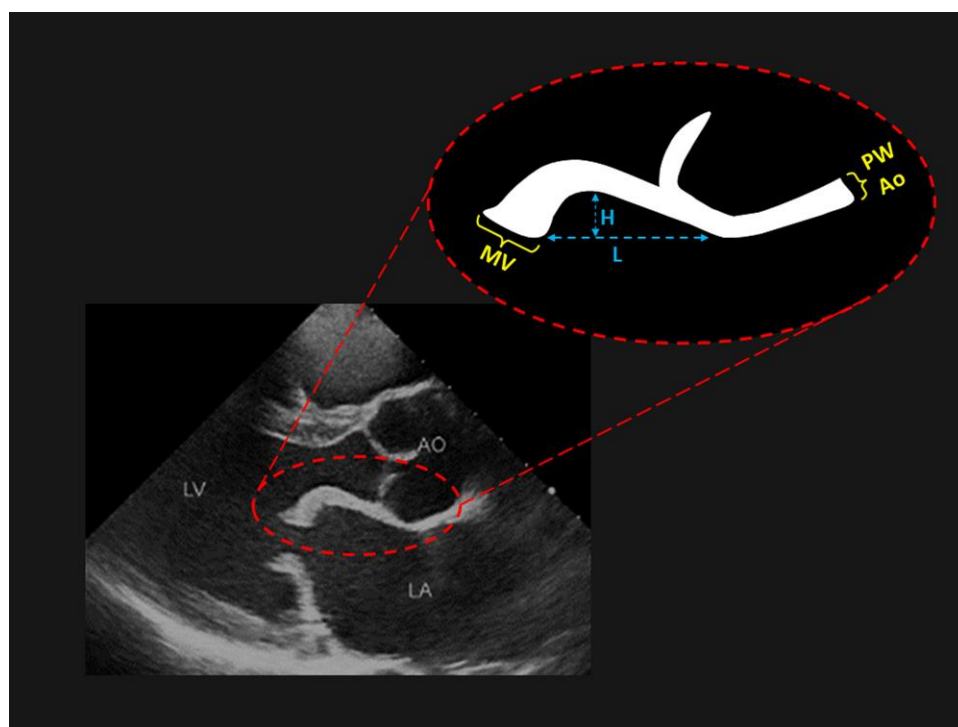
Assessment of AML motion and thickness from parasternal long-axis view (Reid *et al.*³⁵). The slope of leaflet motion is calculated as AML doming height (H) divided by its length (L). AML thickness ratio is calculated as AML tip thickness divided by thickness of posterior aortic wall (PW/Ao).
